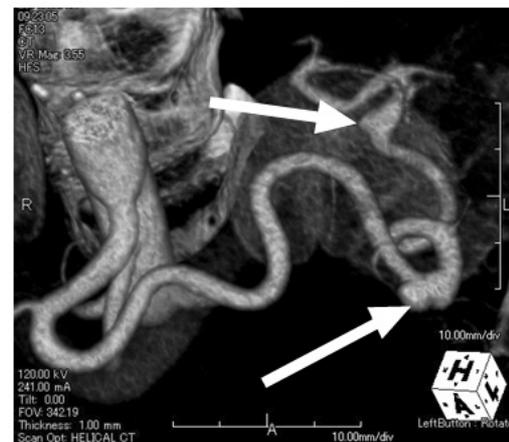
Preoperative CT and MRI images of the splenic vascular lesions.
